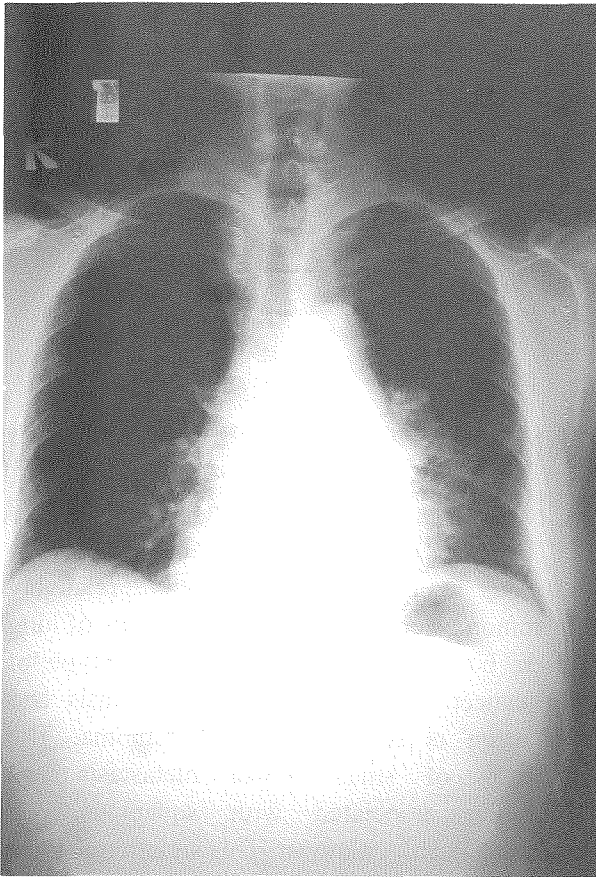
Chest radiograph (PA) shows a mass lesion in the left lower lung field.
